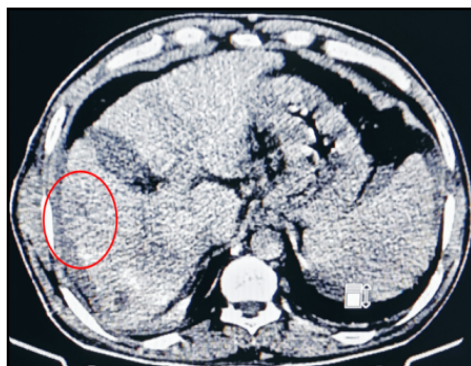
8 CT-scan image of Liver Tumor after Ablation
